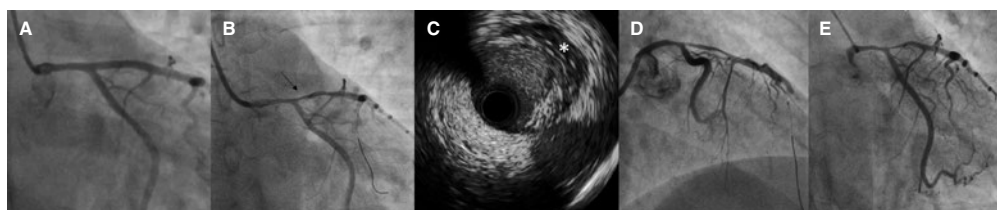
A: diffuse stenosis of the caliber of the left main (LMCA) (50%) and proximal left anterior descending (LAD) (30%) coronary arteries suggestive of the presence of an intramural hematoma. B: coronary angiography reassessment (8 days later) showing additional reduction of the distal LMCA and ostial LAD diameters (arrow) associated with a decreased distal flow after crossing the guidewire to the distal LAD. C: intravascular ultrasound (IVUS) imaging shows the presence of an intramural hematoma (asterisk). D: slow flow (Thrombolysis in Myocardial Infarction flow grade 1) after IVUS imaging due to severe vasospasm. E: slow resolution of the vasospasm after the administration of intracoronary nitrates.
